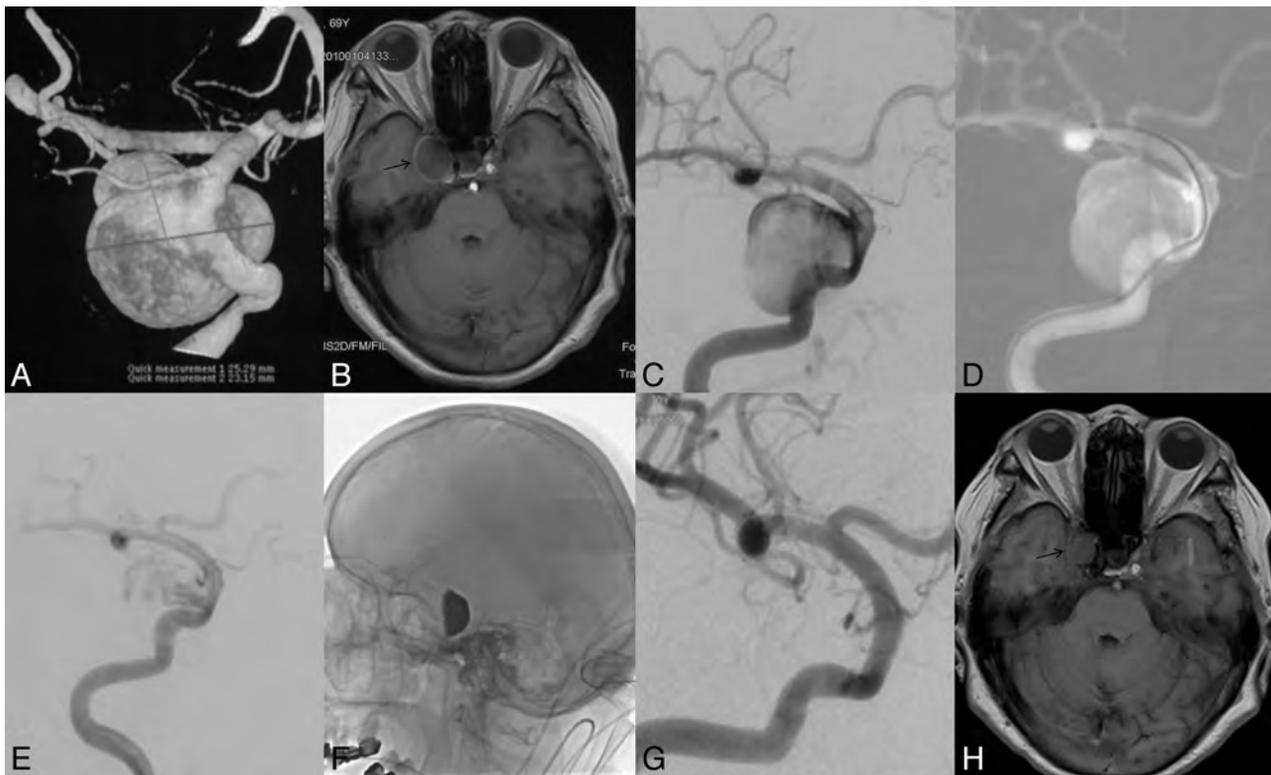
Right internal carotid artery digital subtraction angiography and 3D reconstruction (A–C) reveal a giant cavernous segment aneurysm of approximately 25.3 mm. The microcatheter is delivered across the aneurysmal neck (D), and 1 Tubridge flow diverter is deployed. Postoperative angiography reveals a disrupted inflow jet, slow flow, and flow reduction (E and F). The 23-month follow-up angiography reveals that the aneurysm is completely occluded (G). H, The black arrow points to the patent covered ophthalmic artery during follow-up compared with the preoperative image. MR imaging follow-up shows shrinkage of the aneurysm (black arrow).
